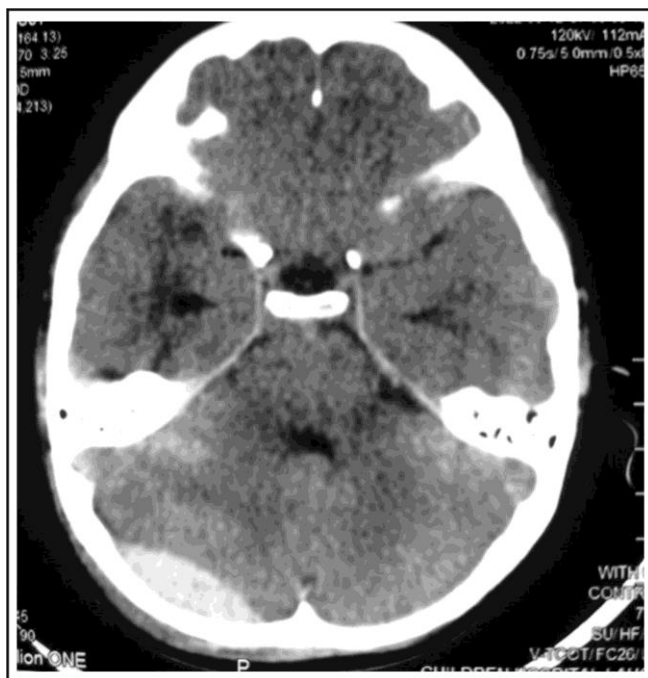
Plain CT brain with Right-sided PFEDH (Image was used after patient consent).
